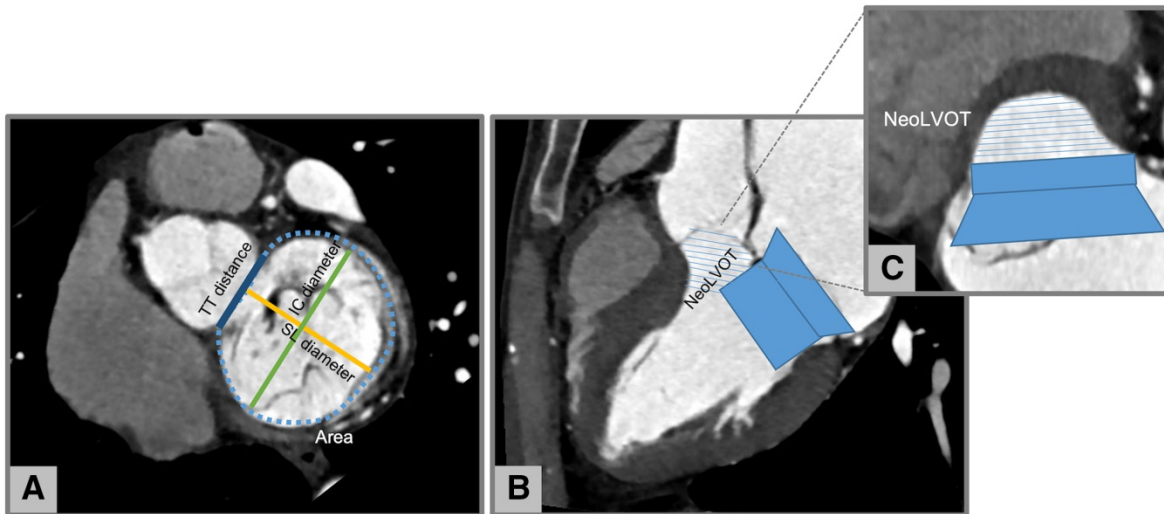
Neo LVOT assessment in native mitral regurgitation with CT. (A) Measurement of mitral annulus size: area, SL, IC, and TT diameters. (B) Virtual valve implantation of TMVR and identification of the neo LVOT (C). Images by courtesy of Antonio Esposito and Anna Palmisano, San Raffaele IRCCS, Milan (Italy). CT, computed tomography; IC, inter-commissural; LVOT, left ventricular outflow tract; SL, septal-lateral; TT, trigone to trigone; TMVR, transcatheter mitral valve repair.
